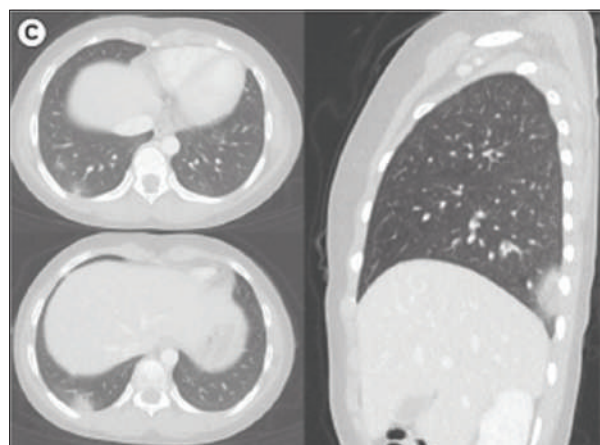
(C) Chest CT performed on the fourth day since symptom onset demonstrates patchy nodular consolidations with peripheral ground glass opacities in subpleural areas of the right lower lobe in axial and sagittal views of CT.^[15]
